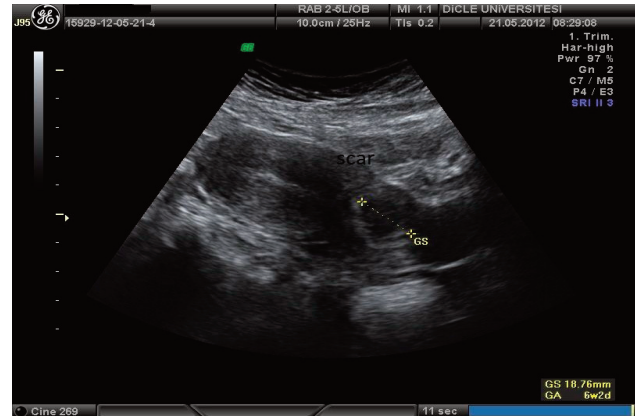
Ultrasonographic view of the gestational sac of CSP in Case 7 is marked.
